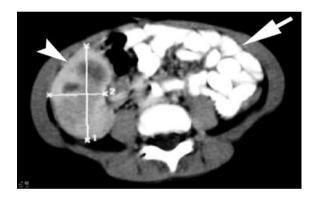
Computed tomography of the abdomen after colonic and intra venous contrast showing an enhancing mass (8x6x3.5cm) (white arrowhead), anterior and inferior to the right kidney, lying over the right psoas. The white arrow points to the bowels filled with contrast material.
